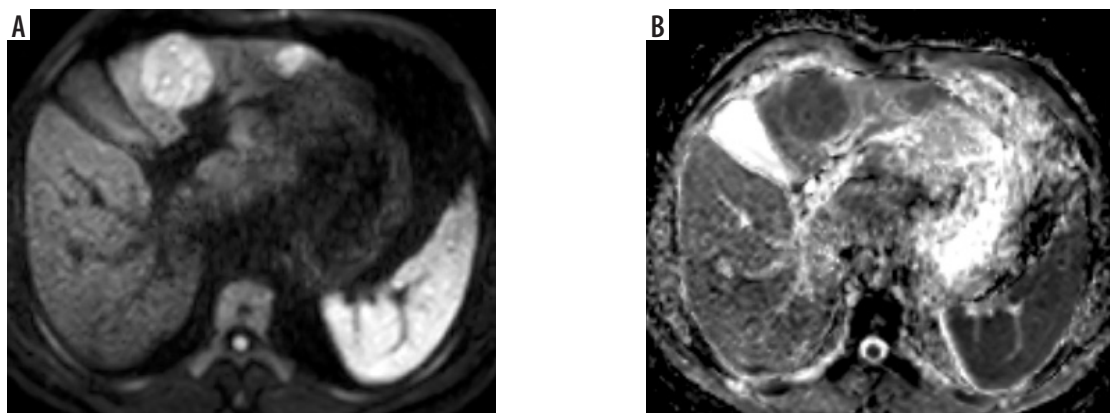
DWI (b value = 600 mm²/s) and ADC map show diffusion restriction of both lesions with ADC values of the large lesion (0.98 and 1.06 x 10⁻³ mm²/s) and for the smaller lesion (1.11 and 1.04 x 10⁻³ mm²/s) by both reviewers, respectively
